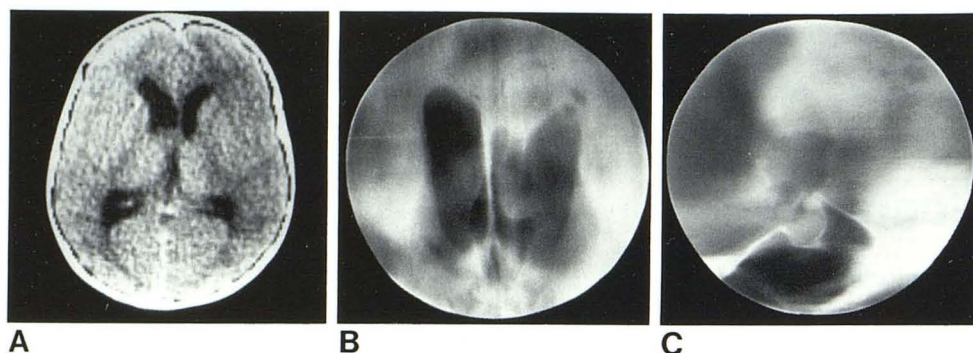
Case 15: colloid cyst of third ventricle attached to left foramen of Monro. A, CT shows deformation of posterior inferior portion of dilated left frontal horn. B and C, Focused encephalography is pathognomonic due to typical deformation of third ventricle.
